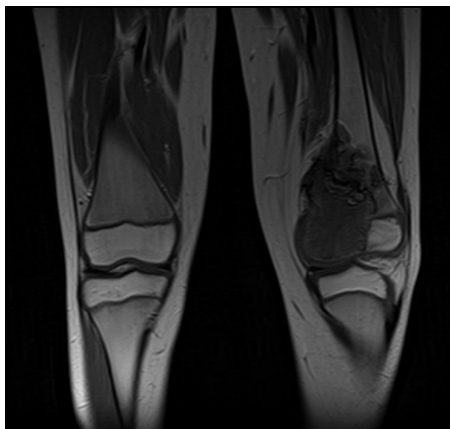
Magnetic resonance imaging is showing diffuse osteolysis of the left distal femur. Biopsy revealed osteosarcoma.
